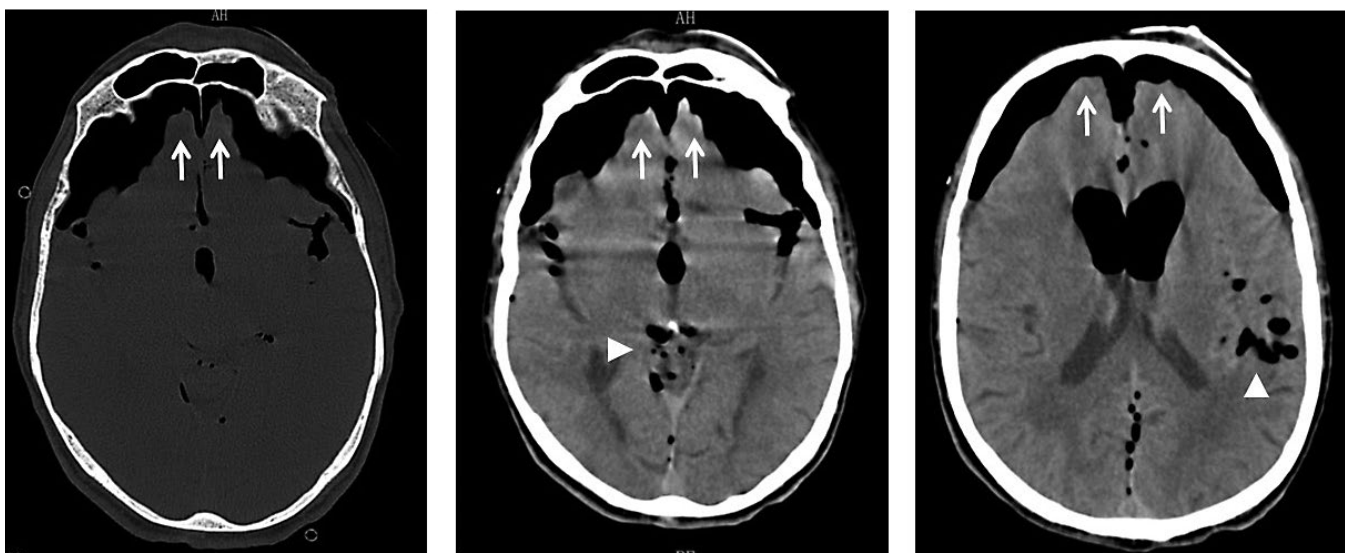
Head CT revealed extensive subdural pneumocephalus bilaterally. The air entrapped causes mass effect, compressing the frontal lobes and widening of the interhemispheric fissure, the “Mount Fuji sign” (arrows). Multiple small foci of air within several cisterns represent the “air bubble sign” (arrowheads). Intraventricular air-fluid level is also present.
